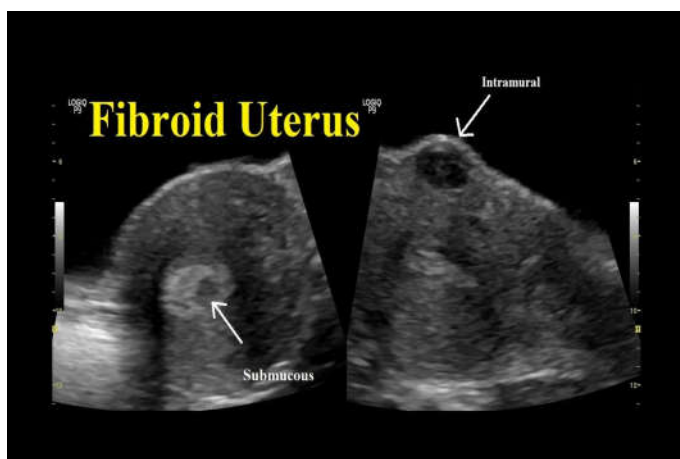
A sonogram showing sub mucosal fibroid in a longitudinal view
